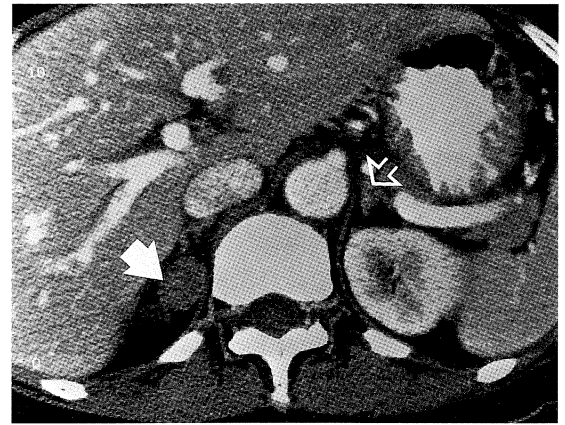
CT scan (3 mm axial section) of the adrenals showing a well-defined hypodense mass arising from the right adrenal gland (arrow), measuring approximately 2.3 cm in largest dimension. The left adrenal gland appears normal (open arrow).
